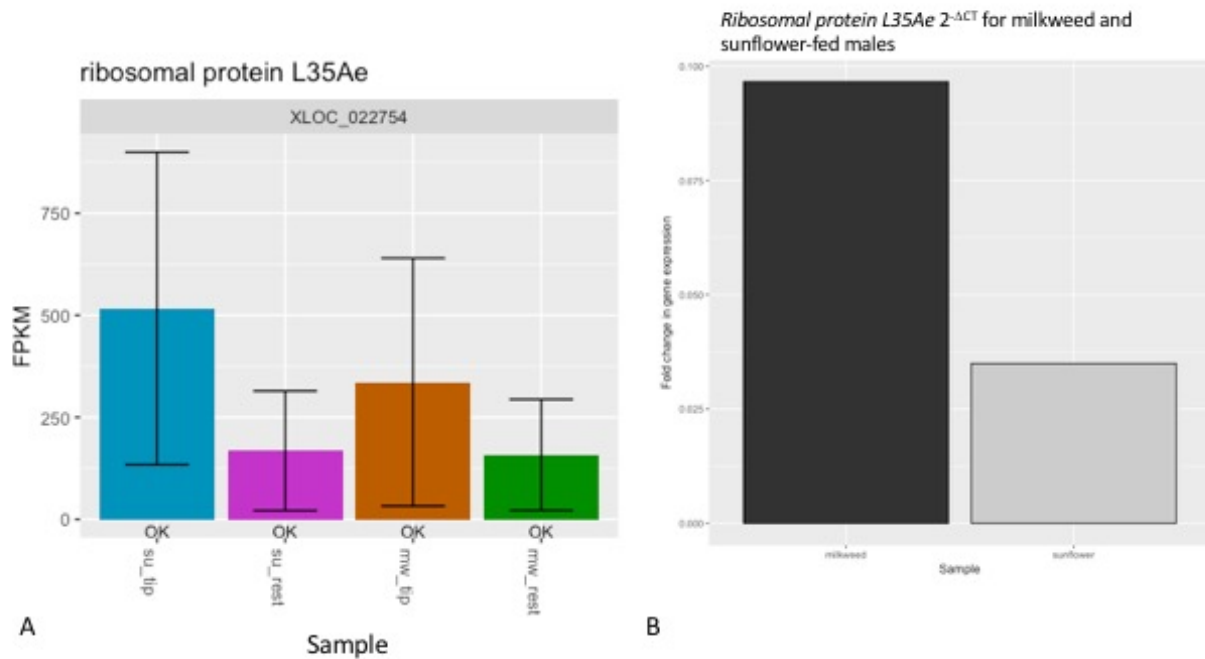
ribosomal protein L35Ae* is more abundant in testis distal tips. (A) Fragment per kilobase million (FPKM) counts for each sample and the (B) $2^{-\Delta CT}$ measurements for *ribosomal protein L35Ae*. The FPKM (A) shows the relative amount of expression per sample; error bars represent the confidence interval for each sample. There is a trend for there to be more transcripts in the sunflower distal tip than in the milkweed distal tip, as well as compared to the sunflower and milkweed proximal rest. The difference in $2^{-\Delta CT}$ values (B) are very small between the milkweed and sunflower-fed males.
